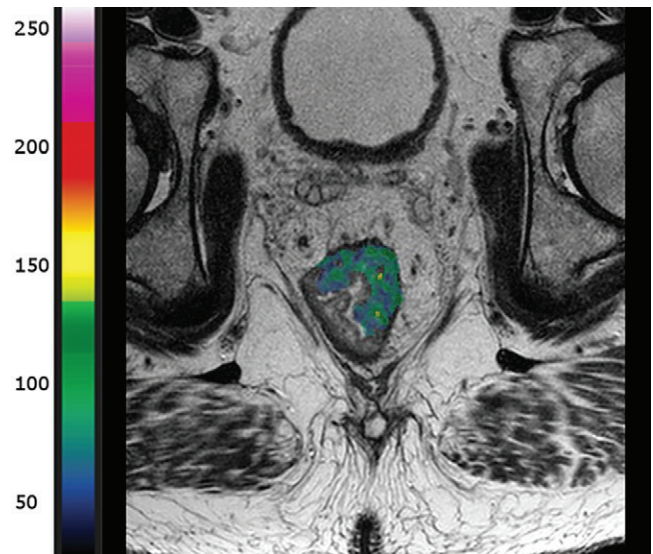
A 64-year-old woman with stage 4 rectal cancer (T3N2M1) with a median tumor blood flow of 140 mL/min/100 g. Image shows calculated tumor blood flow overlaid on an axial T2-weighted anatomic MRI scan. The participant had no disease progression at last follow-up. Color values are indicated on the color bar.
